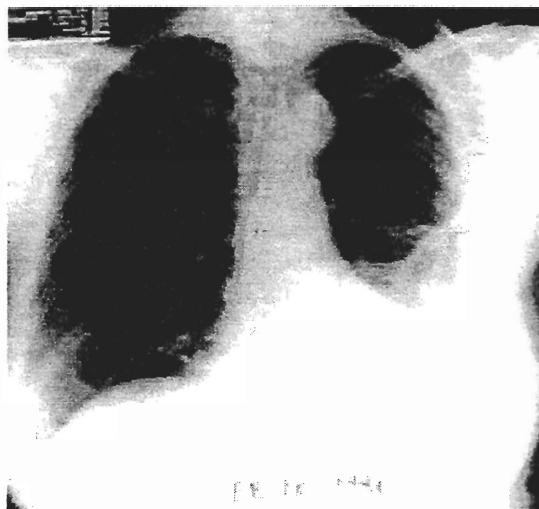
Three months after 22 doses of X-ray therapy (434 MHz followed by 150 rads on Monday/Wednesday/Fridays and 150 rads X-rays only on Thursdays and Fridays to 3300 rads total). The first ever response of this cancer reported in the literature. There was no recurrence one year later. Figures 2, 3, 9, 10, 11 and 12 are reproduced with the Editor's permission from *The Cause of Cancer, Med Hypotheses* 1979; 5: 109–144.
